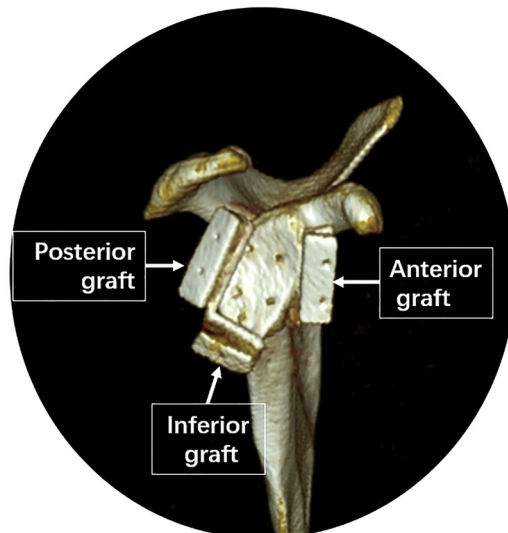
Postoperative 3-dimensional computed tomography of the glenoid with bone grafts (right shoulder).
